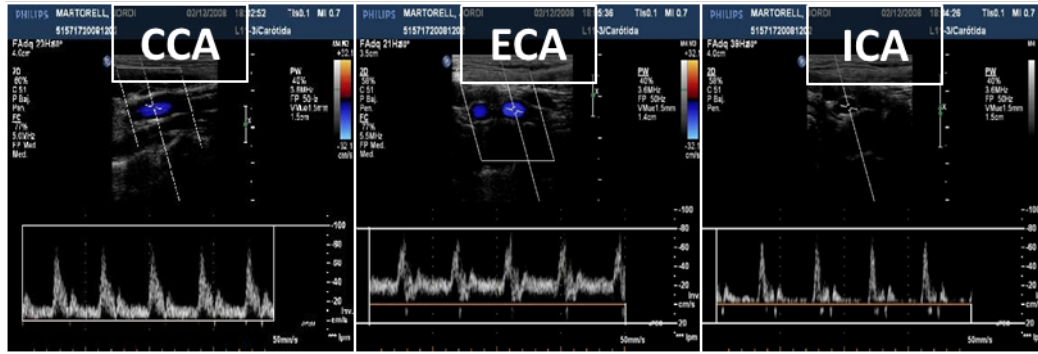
Velocity profiles in the carotid bifurcation using Doppler echography
